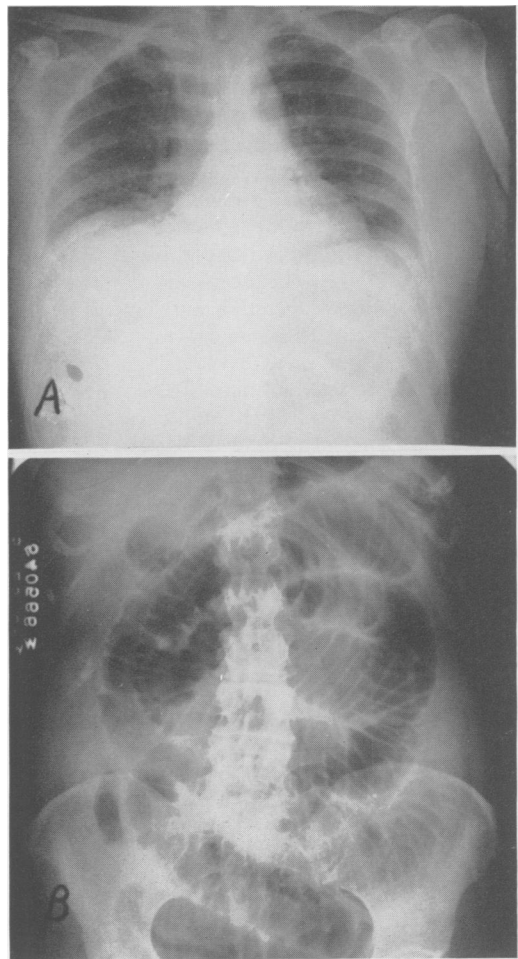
Case 1. X-ray studies on admission. A. Chest x-ray showing minimal atelectasis. B. Scout abdominal film showing dilated bowel.
